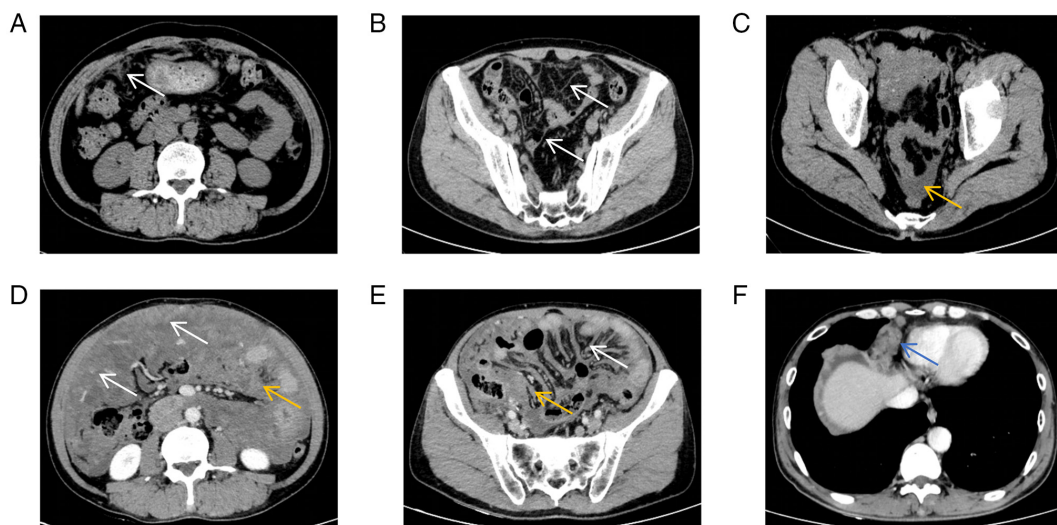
Contrast-enhanced axial abdominal computed tomography scans. (A) Image from July 2020 showed mild striated thickening of the omentum in the upper middle abdomen with minimal surrounding infiltration (white arrows). (B) Image from July 2020 shows striated and nodular thickening of the omentum in the lower abdomen (white arrows). (C) Image from July 2020 shows a small amount of peritoneal fluid in the pelvic cavity (yellow arrow). (D) Image from April 2022 shows marked diffuse thickening of the omentum in the upper middle abdomen (white arrows) and a heterogeneous mass within the omentum (yellow arrow). (E) Image from April 2022 shows irregular sheet like and striated thickening of the omentum with fat stranding in the lower abdomen (white arrows) and a heterogeneous mass within the omentum (yellow arrow). (F) Image from April 2022 shows an enlarged metastatic lymph node at the cardio-phrenic angle (blue arrow).
